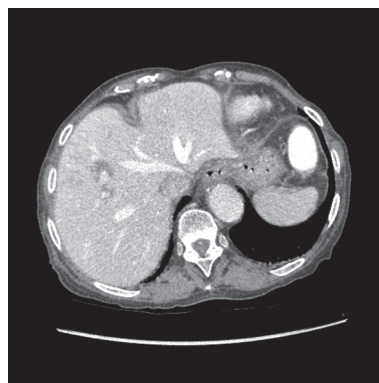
Right hepatic artery branch aneurysm. Transversal view on contrast enhanced abdominal computed tomography exhibiting a 10 mm × 6 mm aneurysm originating from a branch of the right hepatic artery irrigating segment VIII. The darker halo surrounding the aneurysm reflects secondary hepatic parenchyma lower perfusion due to mass effect. The lithiasic gallbladder is not seen on this image.
